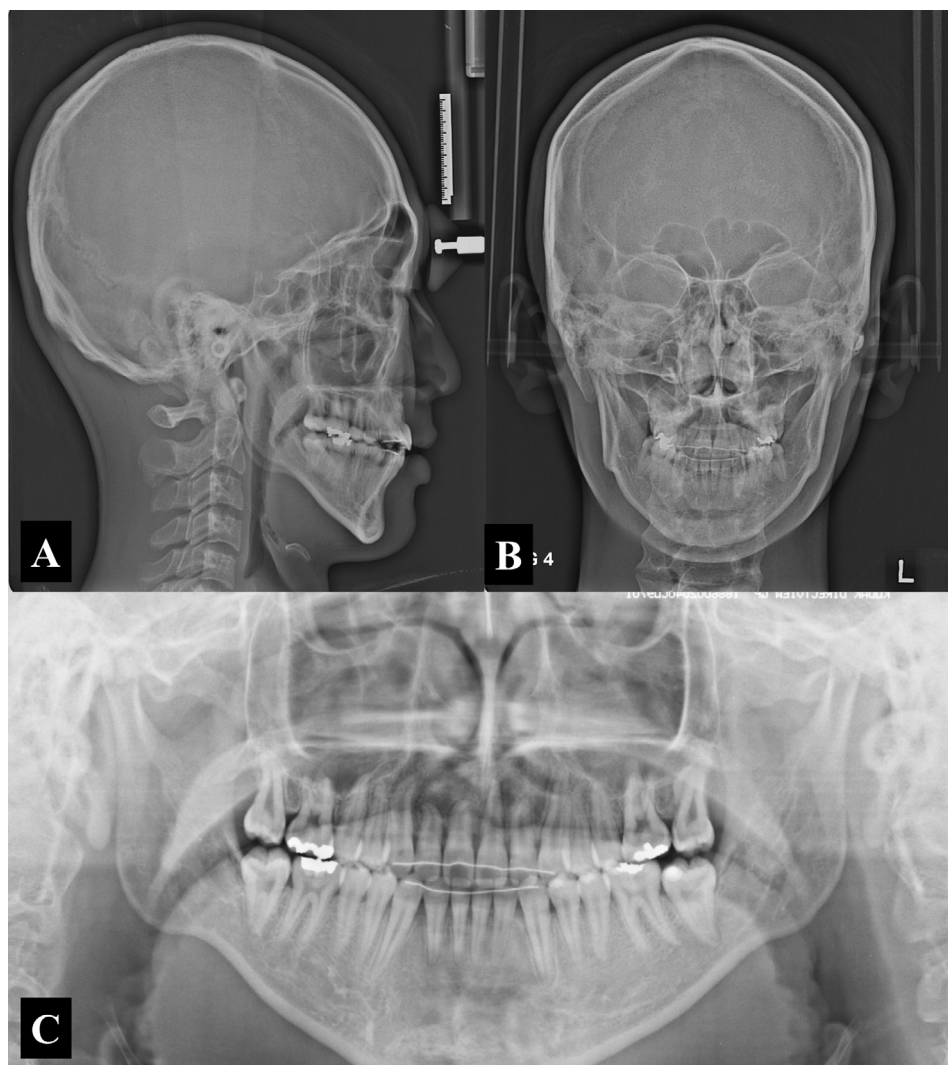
Posttreatment radiograph: (A) lateral cephalogram; (B) postero-anterior cephalogram; and (C) panoramic radiograph.
